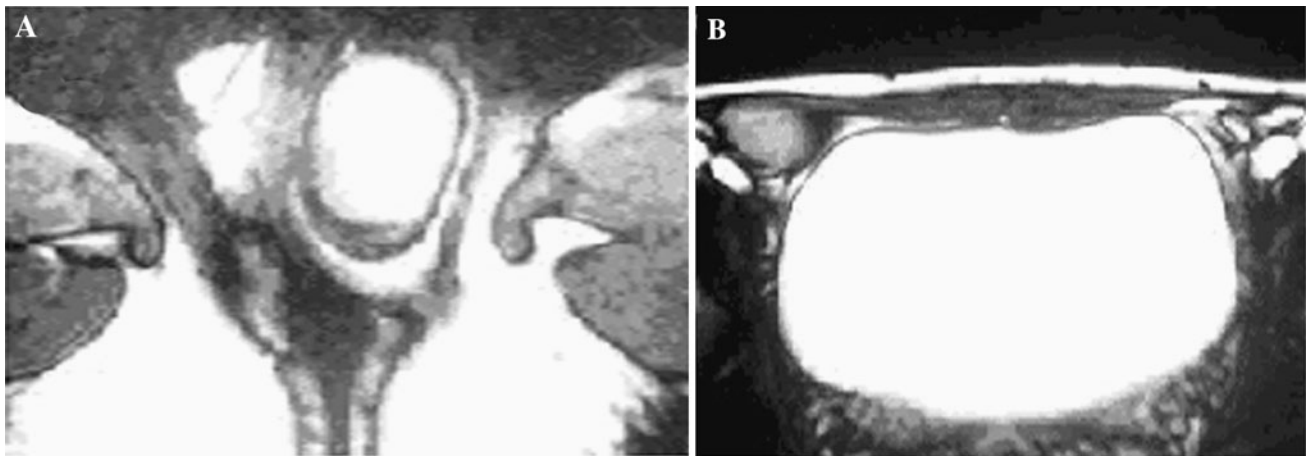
a MRI showing left testes in the labia majora. b MRI showing right testes in the inguinal canal
